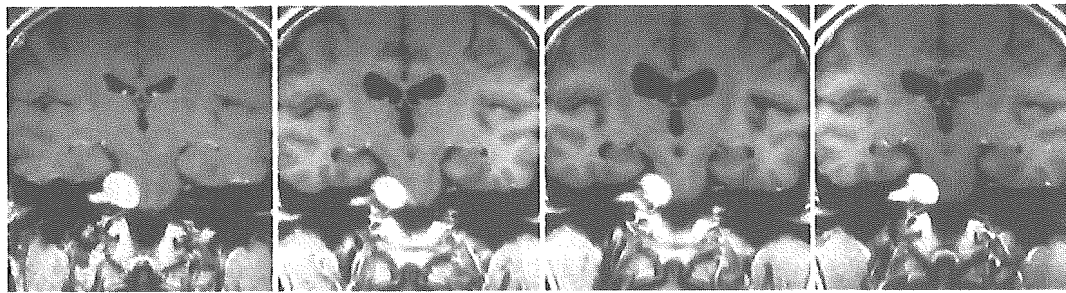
Magnetic resonance images obtained in a 50-year-old woman with a right-sided VS. At the time of SRT, the size of the woman's ventricles was normal (left), but began to increase 15 months after therapy (center left). Twenty-seven months posttherapy the ventricles have enlarged to their greatest size and the patient's total intelligence quotient is 108 without any symptoms related to the ventricular dilation (center right). Forty-three months posttherapy the ventricles have decreased in size (right).
